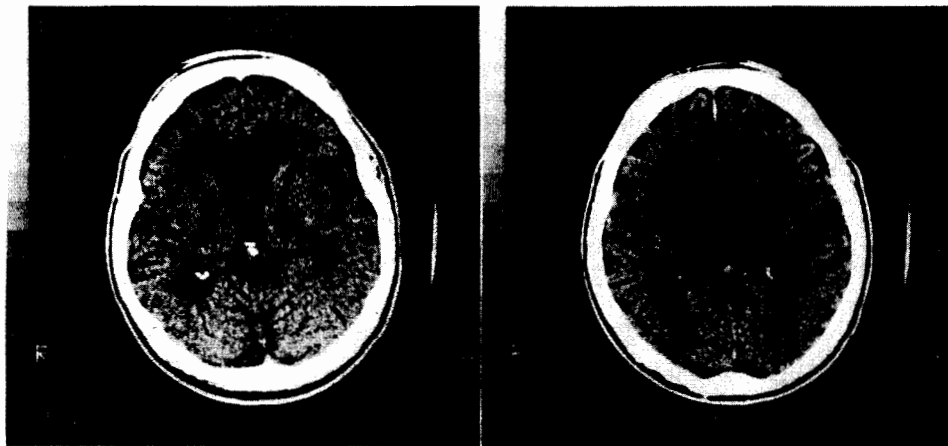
CT scan of patient B.G. taken near the time of testing shows moderate cortical atrophy, ventricular enlargement and no evidence of focal abnormalities.
